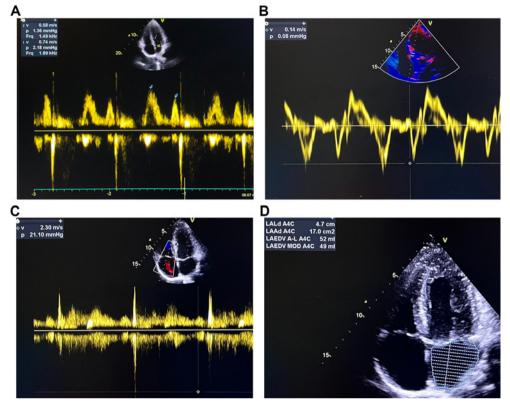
A: TTE examination of flow velocity across the mitral valve (E/A ratio in normal range) in the apical four chamber view using pulse wave Doppler. B: TTE examination of mitral annular velocities obtained using tissue Doppler (e' = 0.14 m/second). C: TTE examination of flow velocity across the tricuspid valve (TR velocity in normal range) in the apical four chamber view using continuous wave Doppler. D: TTE examination of LA volume in 2D mode in the apical four chamber view.
